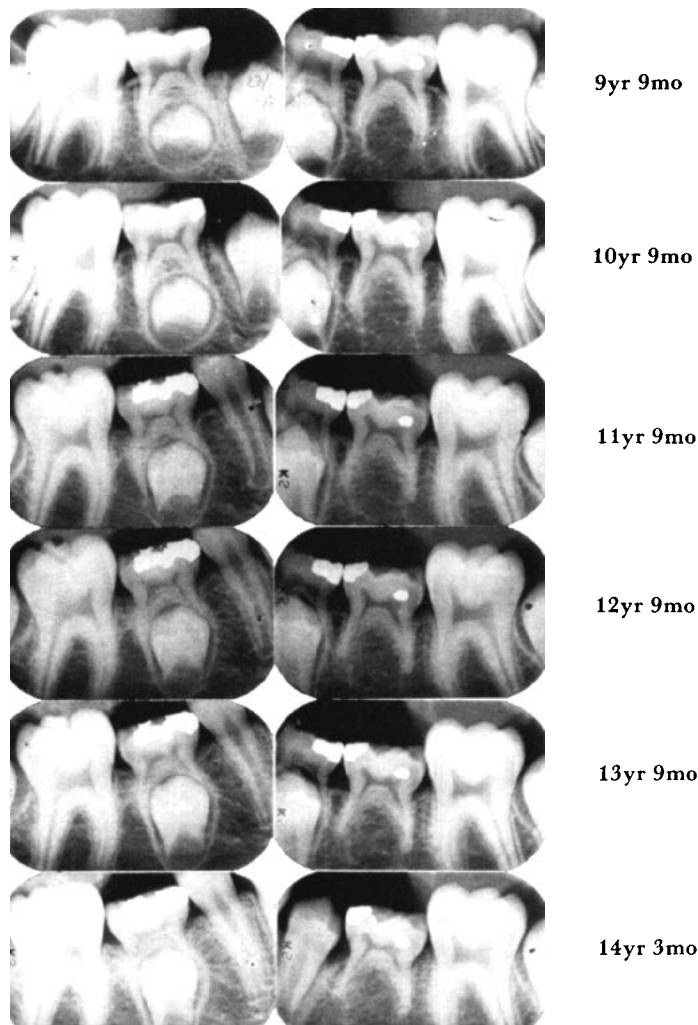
Periapical radiographs of a boy from 9yr 9mo to 14yr 3 mo of age. Note the infraocclusion on each side, and slow resorption of tooth 75. Percussion sounds indicated ankylosis of all infraoccluded deciduous molars.
